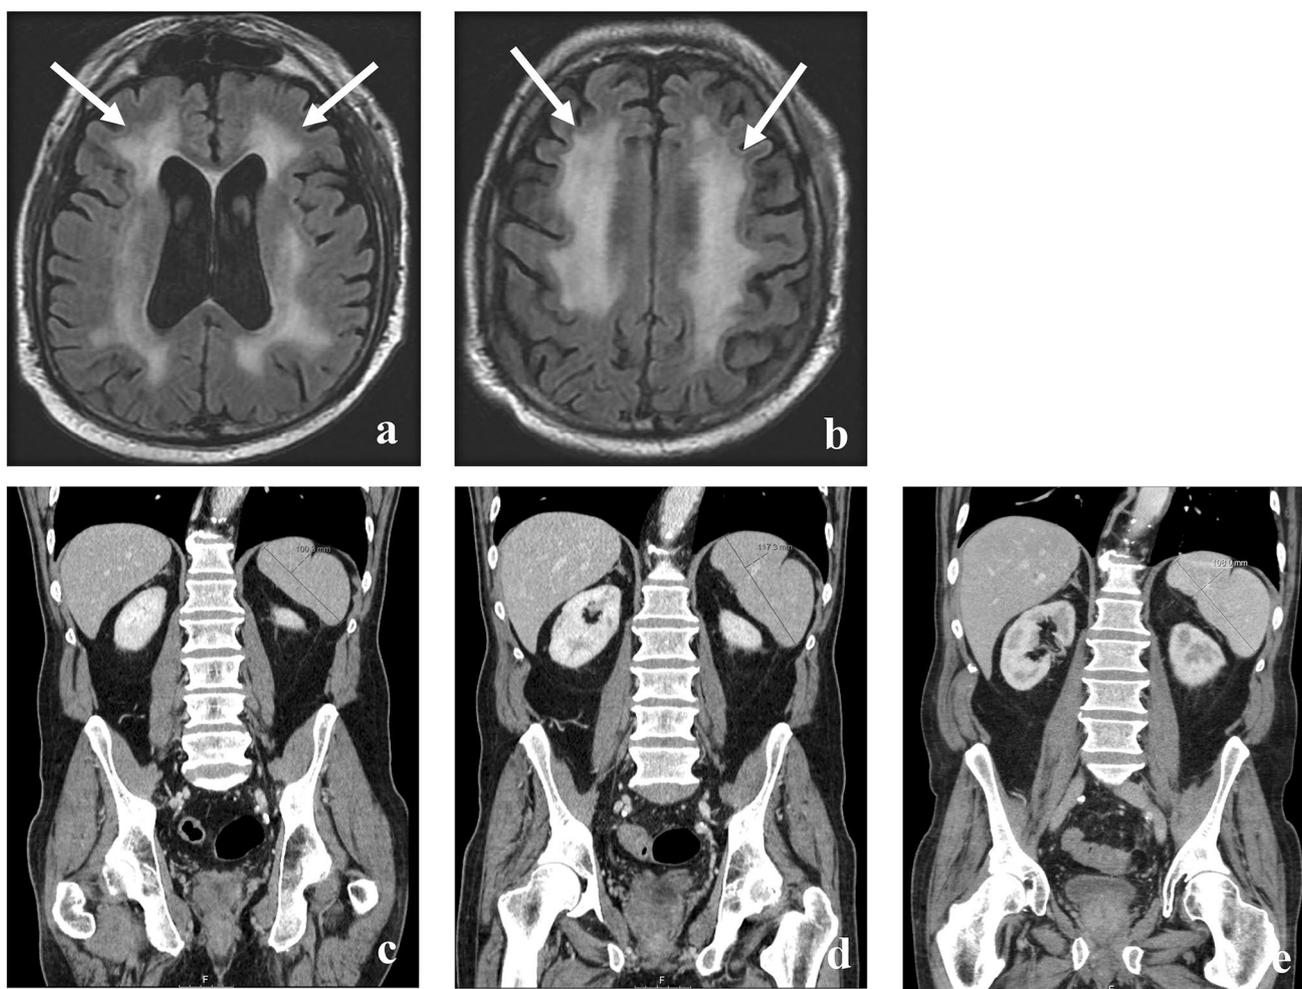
A 64-year-old male with a history of metastatic pancreatic cancer who developed fluorouracil-associated acute neurotoxicity and oxaliplatin-associated splenomegaly. Axial FLAIR MR images obtained several days after initiation of fluorouracil/oxaliplatin demonstrate new white matter changes with symmetrical high signal intensity in the periventricular region and deep white matter (arrows in a, b). Given the sudden onset of these findings following therapy initiation, the patient was diagnosed with fluorouracil-associated
